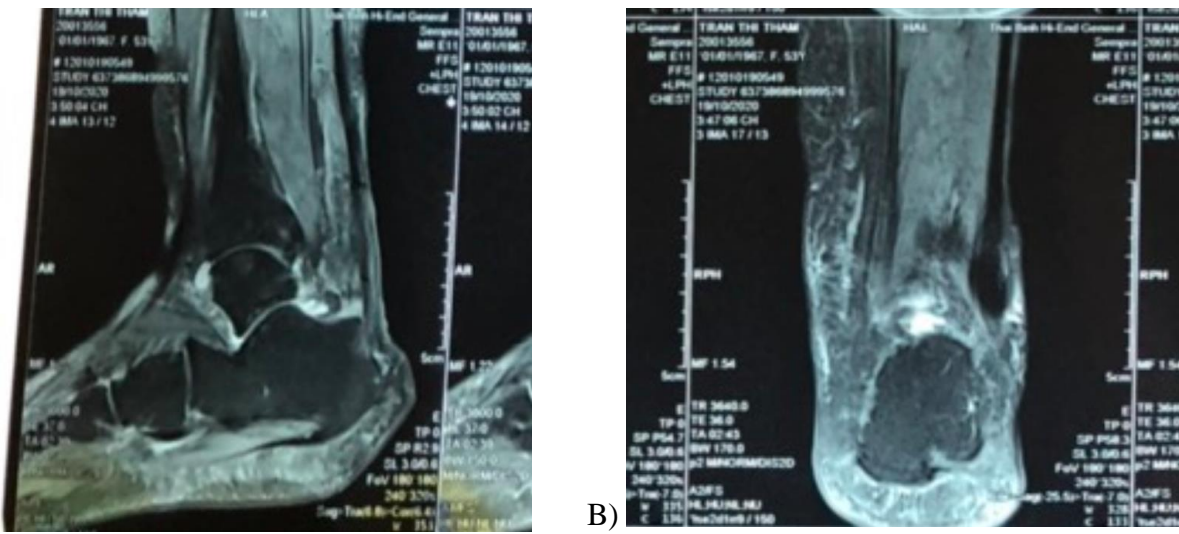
MRI of the right leg after flap reconstruction.
